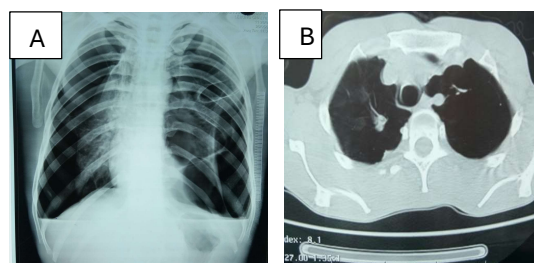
Showing B/L pneumothorax in [A]: Chest X-ray and [B]: CT scan.
